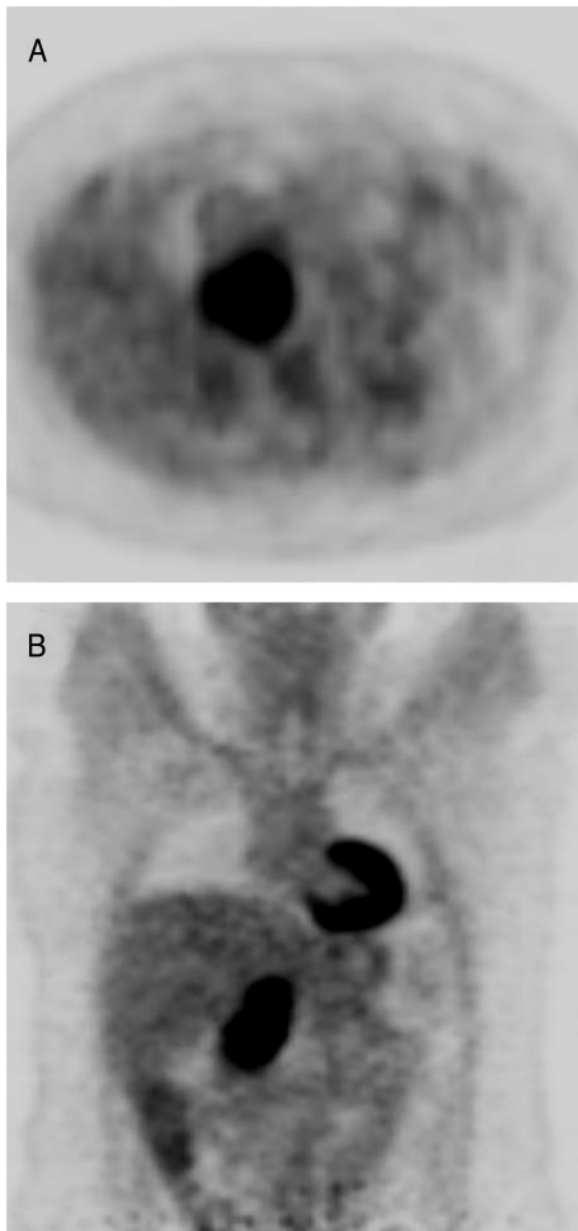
Patient 7, true-positive FDG PET. Axial (A) and coronal (B) FDG PET images demonstrate intense metabolic activity in the right adrenal bed caused by recurrent adrenocortical carcinoma.
